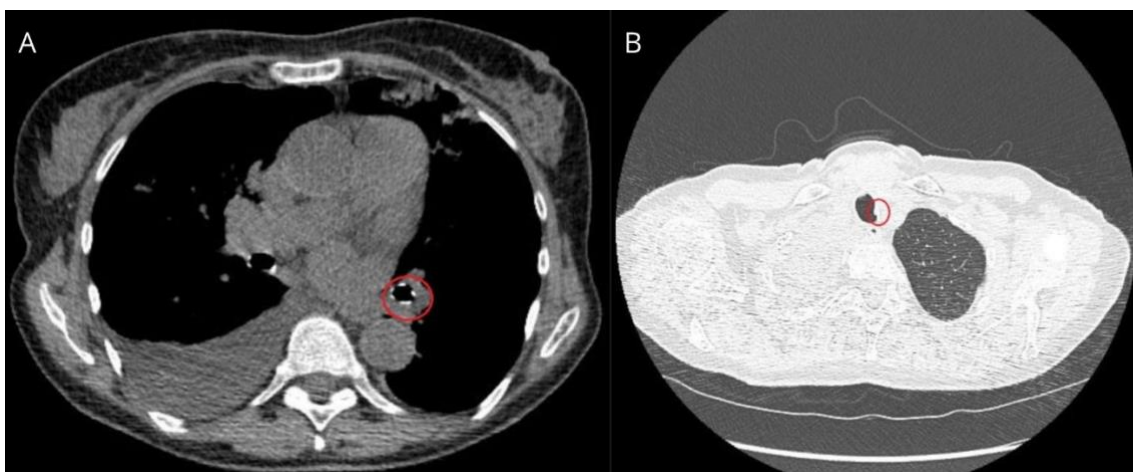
Computed tomography showing irregular nodules involving the tracheal wall with preservation of the posterior membranous wall, with calcified nodules in the left bronchus (A) and a small nodular prominence on the right tracheal wall (B).
